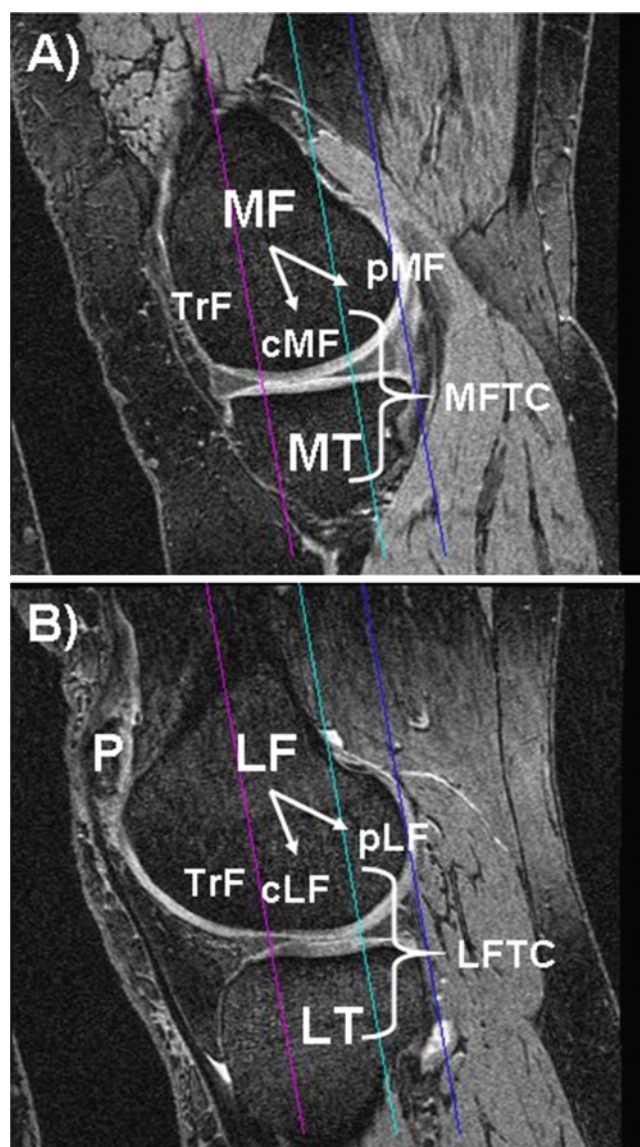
Sagittal 3D DESS MR images showing anatomical regions of interest commonly analyzed: (a) medial femorotibial compartment, (b) lateral femorotibial compartment; *P* patella, *TrF* femoral trochlear, *MT* medial tibia, *MF* medial femoral condyle, *cMF* weight-bearing part of the medial femoral condyle, *pMF* posterior part of the medial femoral condyle, *MFTC* *cMF* + *MT*, *LT* lateral tibia, *LF* lateral femoral condyle, *cLF* weight-bearing part of the lateral femoral condyle, *pLF* posterior part of the lateral femoral condyle, *LFTC* *cLF* + *LT*; the magenta line shows the projection of the trochlear notch, the blue line the posterior end of the medial and lateral femoral condyle, and the turquoise line the 60% criterion (of the distance between the trochlear notch and the posterior ends of the condyles) used to separate *cMF* from *pMF*, and *cLF* from *pLF*, respectively. Images are from the Osteoarthritis Initiative (OAI), a public–private partnership funded by the National Institutes of Health and conducted by the OAI Study Investigators. For anatomical (region of interest) labels, also see Fig. 11.1
